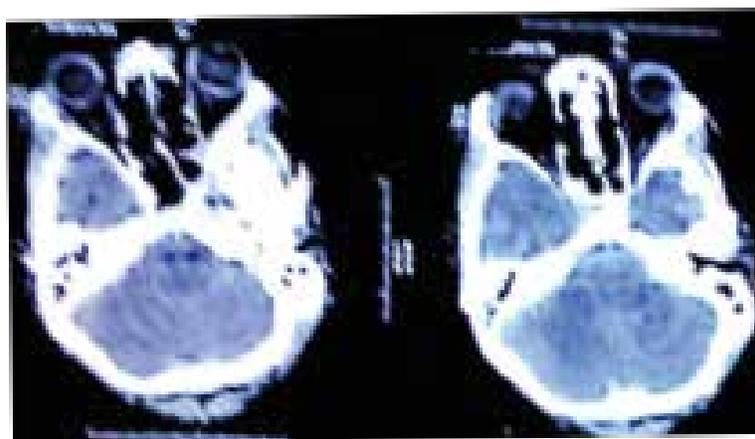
CT Brain plain showed hyperdense lesion in vitreous body
